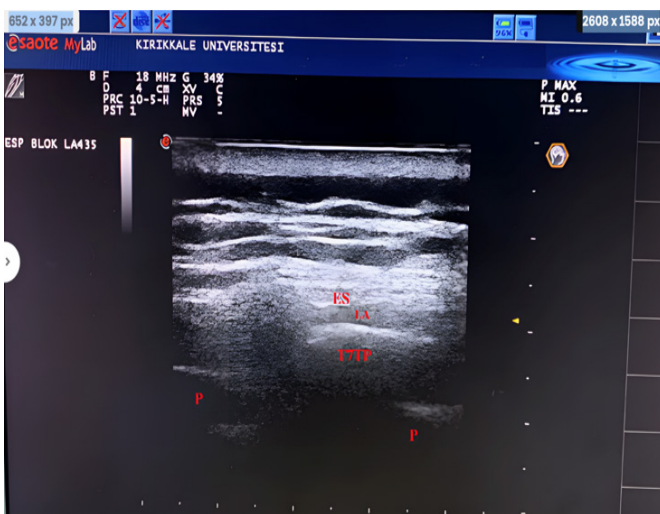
Ultrasonography image of local anesthetic distribution after ESPB
